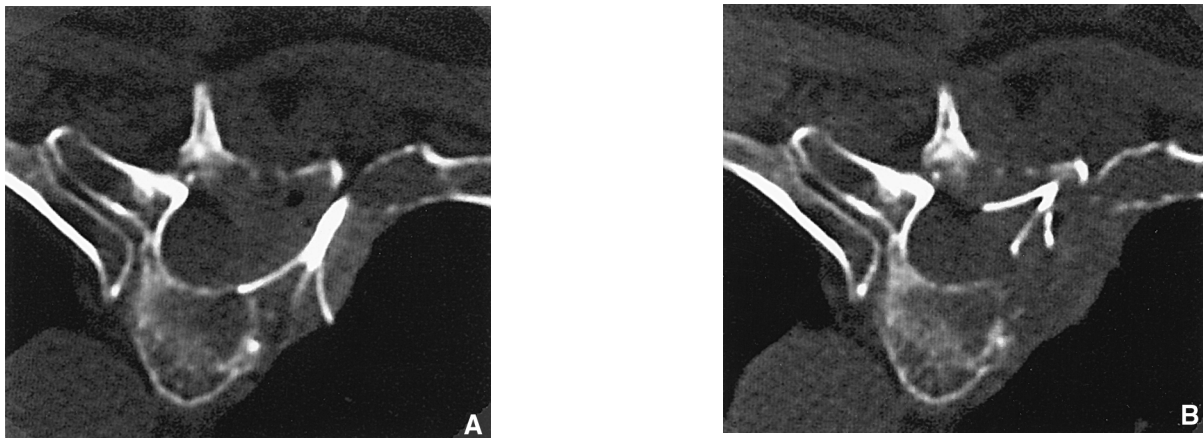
Intraoperative computed tomographic (CT) image of vertebral body T4 showing the deployed array electrodes in direct proximity to the spinal cord, the pleura, and the spinal nerves (A). Because of multislice CT imaging, a precise placement of the radiofrequency system is possible without injuring nearby sensitive structures. An overlapping, larger lesion was obtained by repeated ablation after catheter replacement (B).
